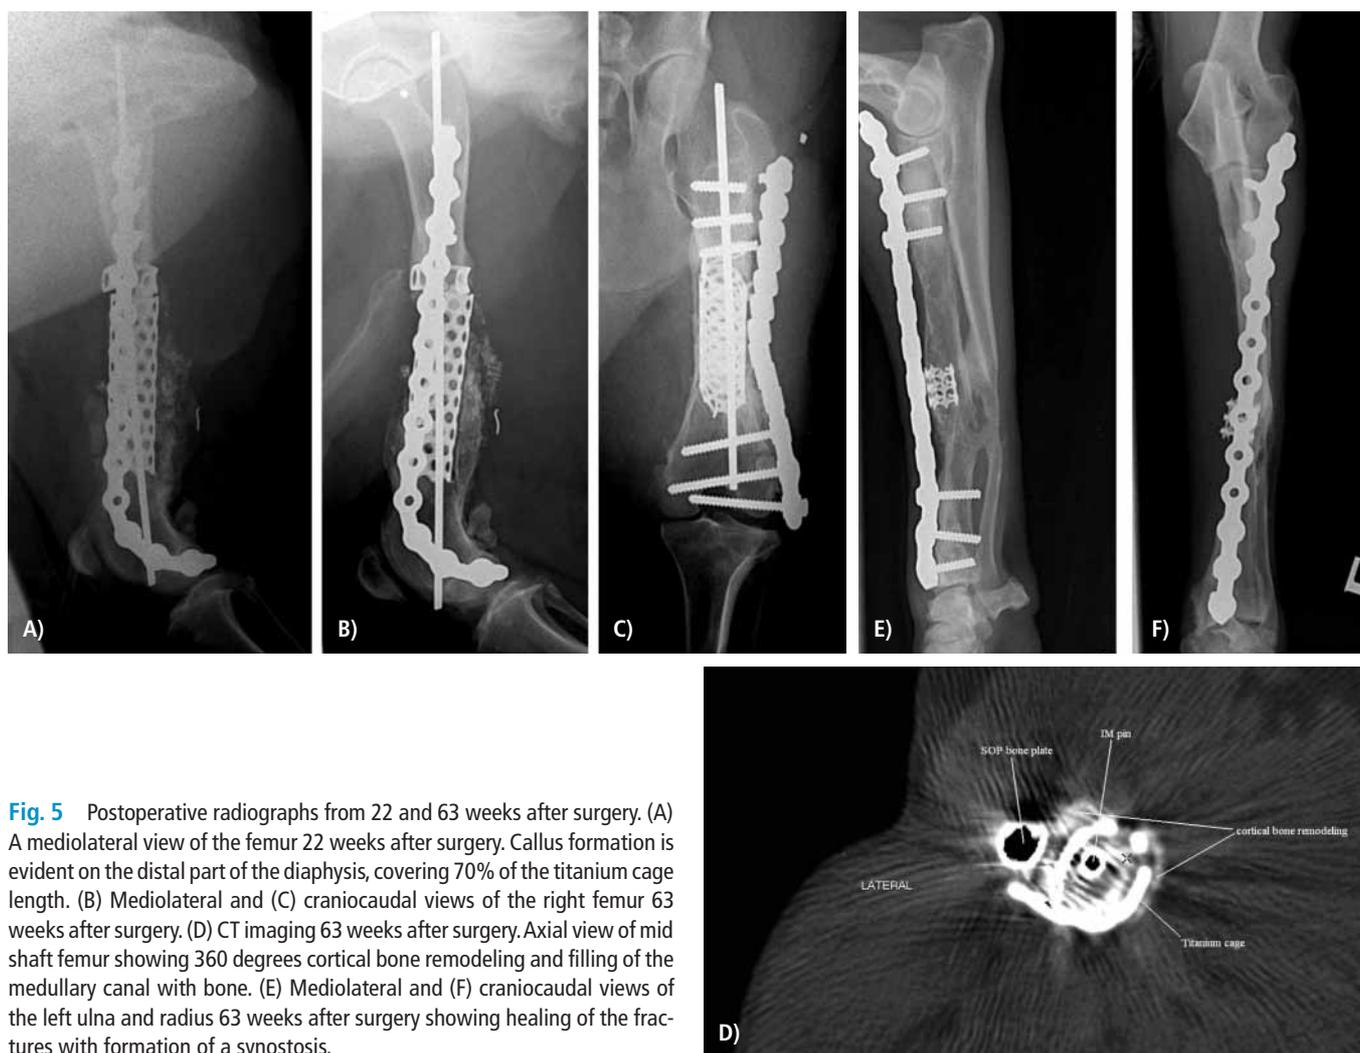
Postoperative radiographs from 22 and 63 weeks after surgery. (A) A mediolateral view of the femur 22 weeks after surgery. Callus formation is evident on the distal part of the diaphysis, covering 70% of the titanium cage length. (B) Mediolateral and (C) craniocaudal views of the right femur 63 weeks after surgery. (D) CT imaging 63 weeks after surgery. Axial view of mid shaft femur showing 360 degrees cortical bone remodeling and filling of the medullary canal with bone. (E) Mediolateral and (F) craniocaudal views of the left ulna and radius 63 weeks after surgery showing healing of the fractures with formation of a synostosis.
